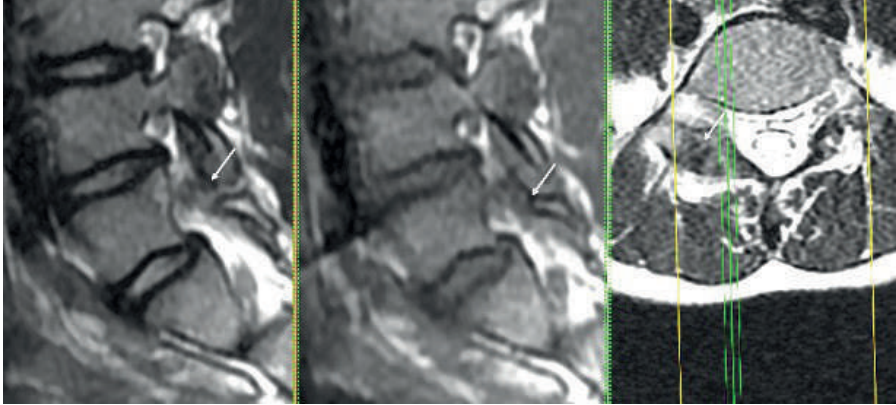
MRI demonstration of pars interarticularis defect.
